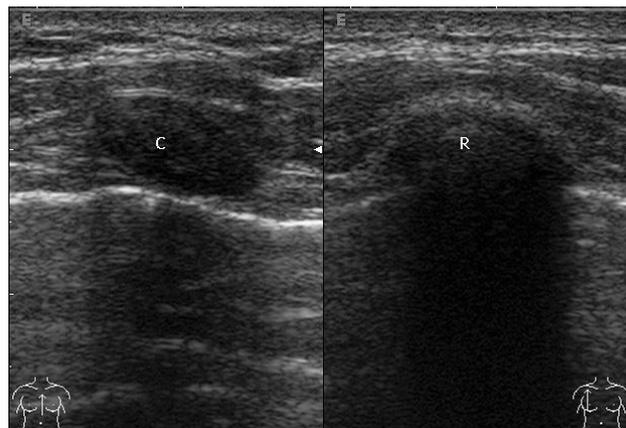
Linear probe in an anterior longitudinal scan (a). Corresponding sonographic image, the sliding line of the visceral pleura can be seen (b) below the cartilage (C) of the ribs (R).
